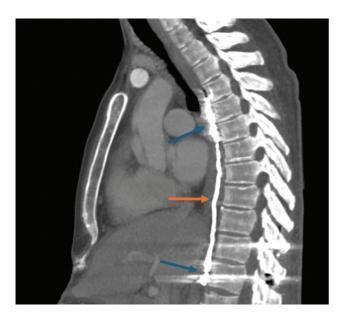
Maximum intensity projection (MIP) reconstruction from a computed tomography (CT) scan. The Obsidio embolic (*orange*) demonstrates significantly less streak artifact compared with the proximal and distal coil packs (*blue*), allowing for better visualization of surrounding structures.
